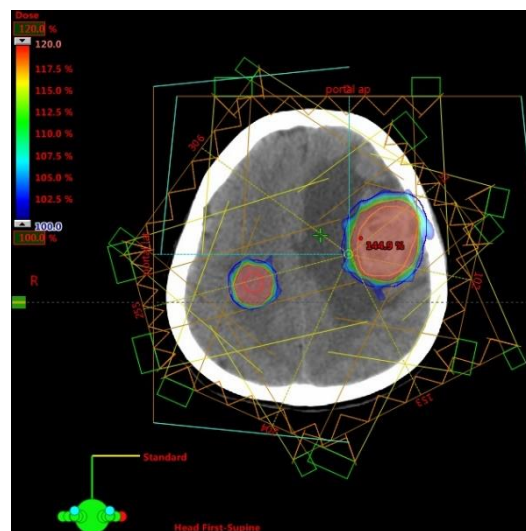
An IMRT plan was generated, using 7 x-ray beams beams of 6 MV and 400MU/min dose rate.
